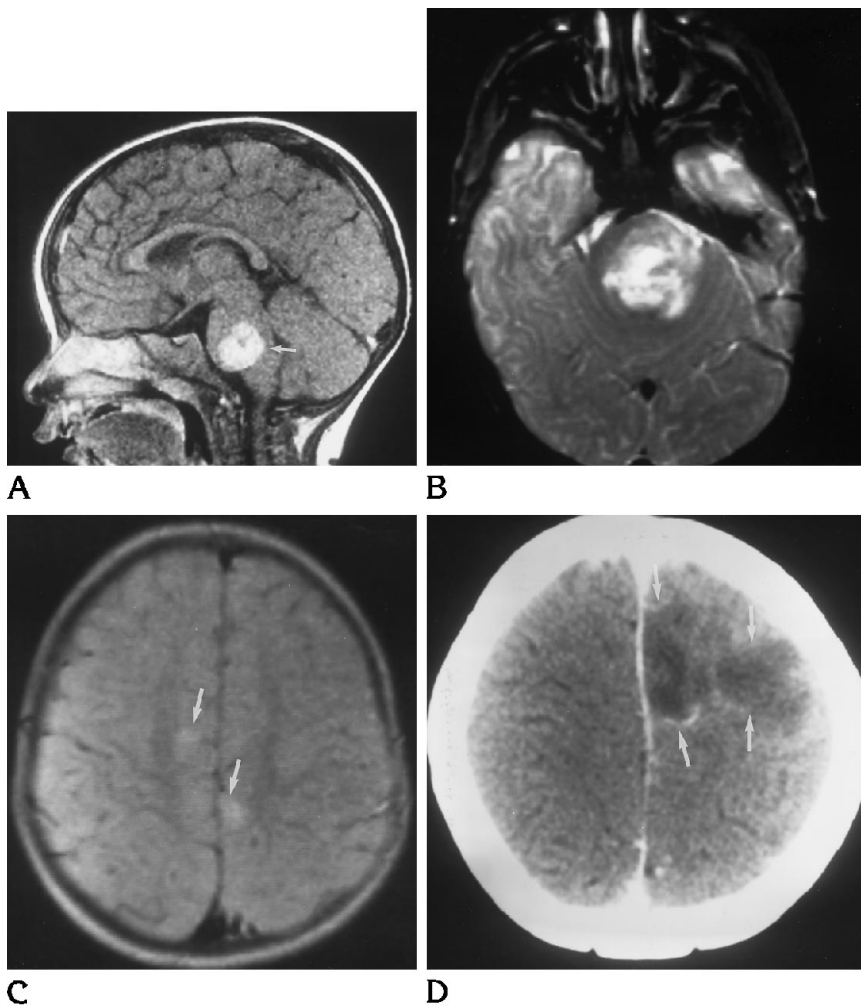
A, Sagittal postgadolinium T1-weighted (500/30/2) (arrows) image shows an enhancing lesion within the pons.
